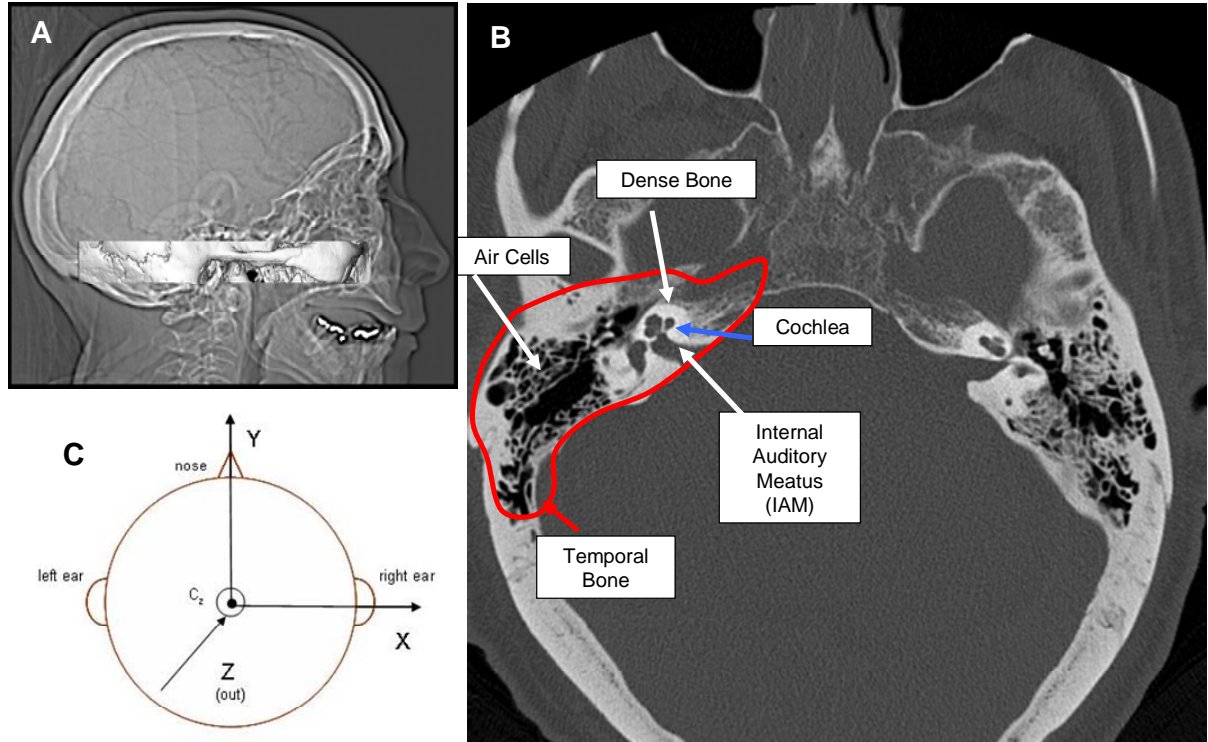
CT image – A: transverse section through the head, B – cross-sectional view through the left cochlea, and C: head coordinate system
